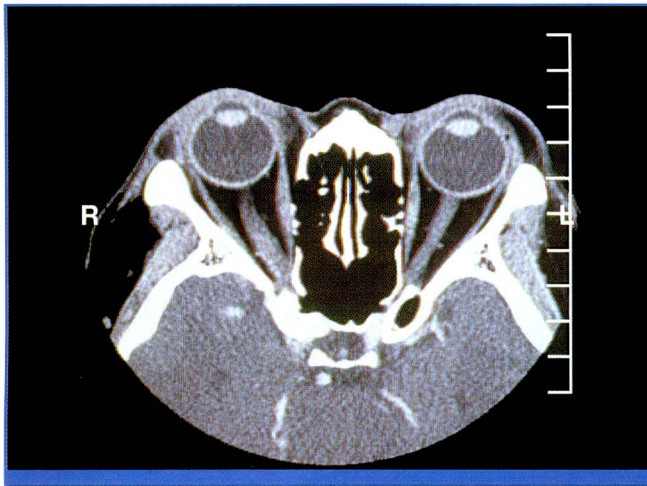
Computed tomography scan showing right optic nerve sheath meningioma — note thickened nerve.
